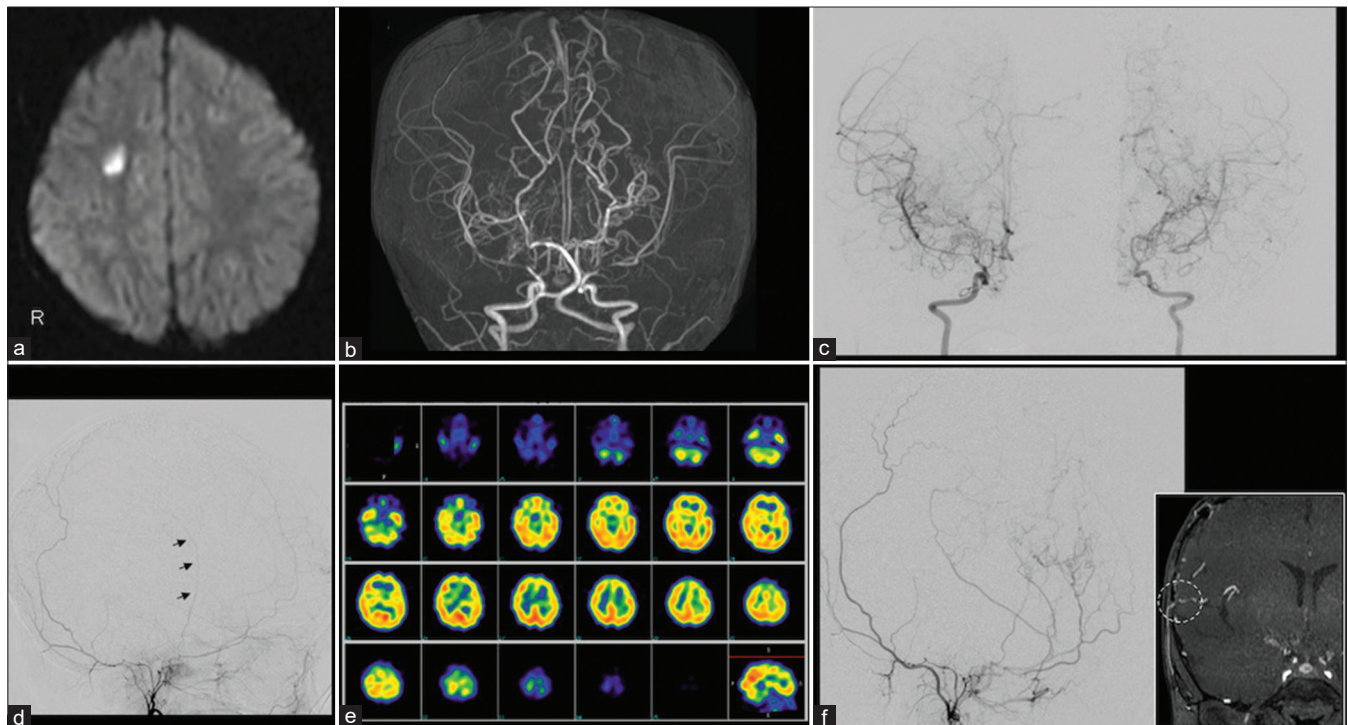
(a) Magnetic resonance imaging of the head showing acute cerebral infarction in the white matter of the right cerebral hemisphere. (b and c) Magnetic resonance angiography (MRA) of the head and digital subtraction angiography (DSA) show unclear delineation beyond the peripheral portions of the bilateral internal carotid arteries. (d) Left external carotid angiography shows that the superficial temporal artery is very thin (arrows). (e) Single-photon emission computed tomography with N-isopropyl-p-[123I] iodoamphetamine showed reduced blood flow at rest in the bilateral anterior and middle cerebral artery regions. (f) MRA and DSA at three months postoperatively showed good blood flow in the bypass area and collateral blood flow development (arrows, dashed circle).
